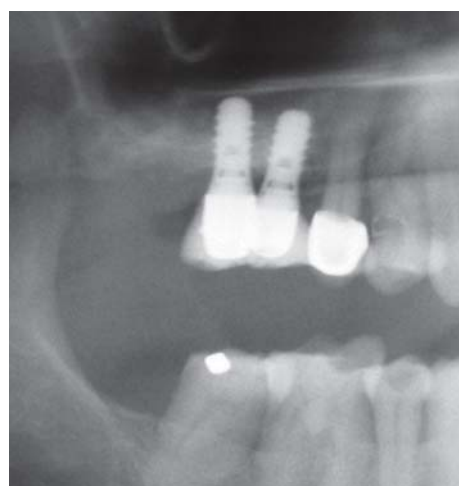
Radiograph showing a stable clinical situation 2 years after treatment and substantial increase in bone volume compared to the initial situation
